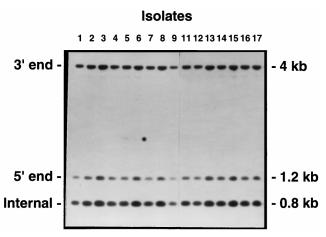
Southern blots probed with ERG16. Genomic DNA (10 μg) was digested with HincII, electrophoresed through an agarose gel, blotted onto nitrocellulose, and probed with labeled DNA from ERG16. The blots were washed and exposed to X-ray film. Slight variations in the intensity of each lane correspond with slight variations in the amount of DNA that was loaded in the gel (45).
